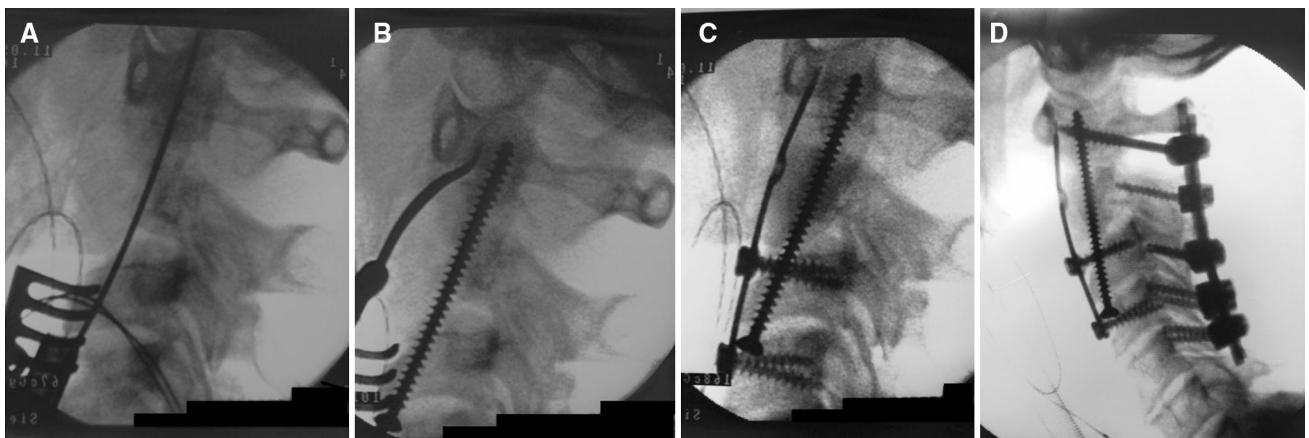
Intra-operative sagittal X-rays showing the insertion of a K-wire from C3 to the odontoid process (a) followed by a 60mm cannulated screw (b), Final aspect after the anterior approach (c), and the posterior approach (d)
